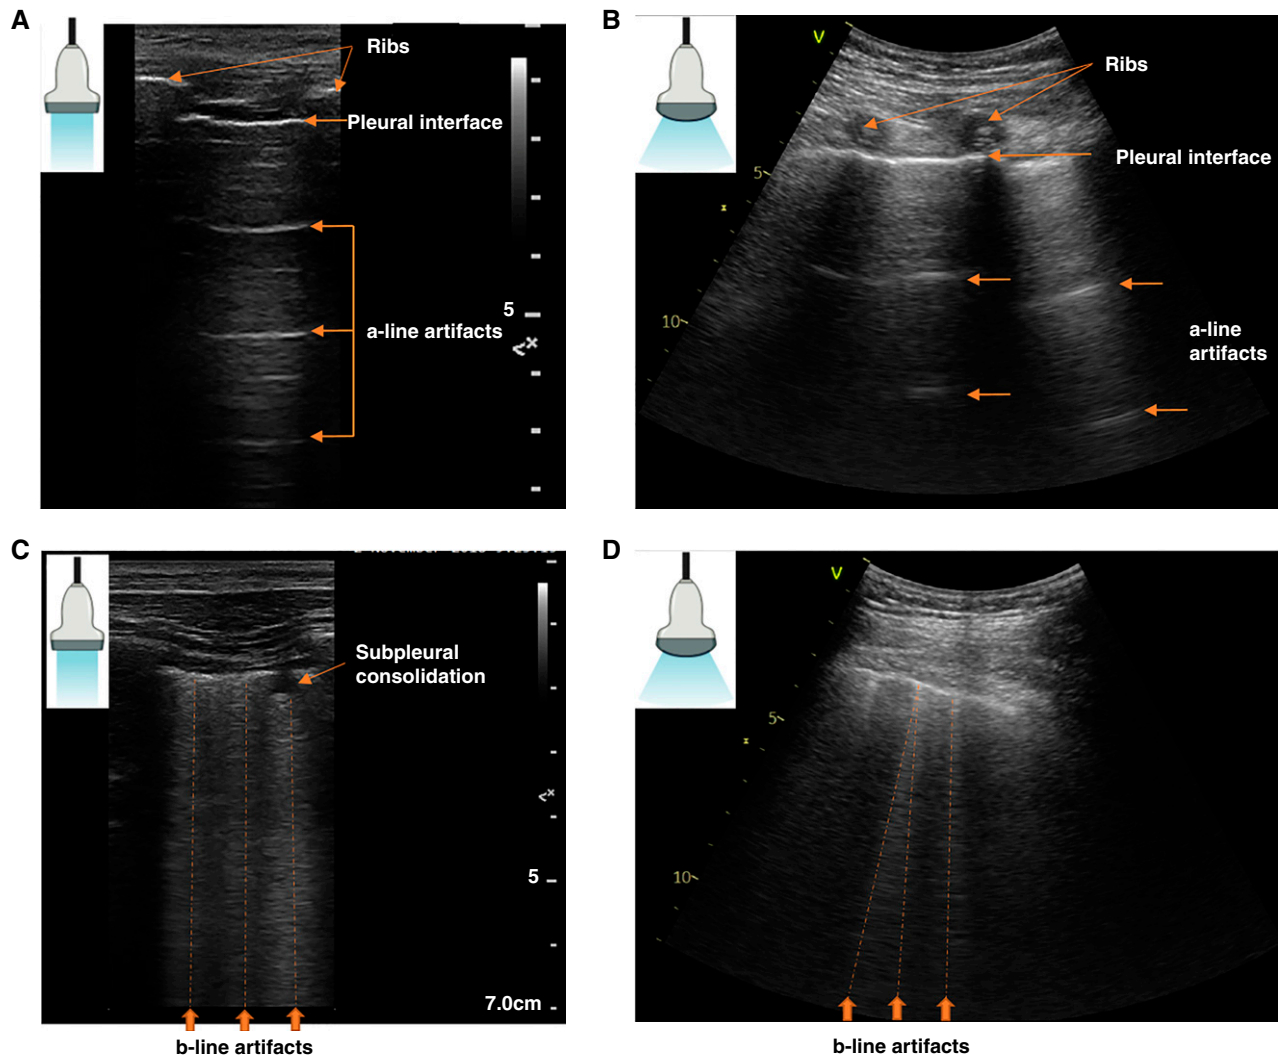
Lung ultrasound using a (A) linear and (B) curvilinear probe. The normal appearance included the rib shadow, the pleural interface with the pleural sliding motion, and horizontal A-line artifacts. (C and D) The presence of interstitial-alveolar syndrome is associated with the appearance of vertical B-line artifacts that arise from the pleura and move with respiration.
